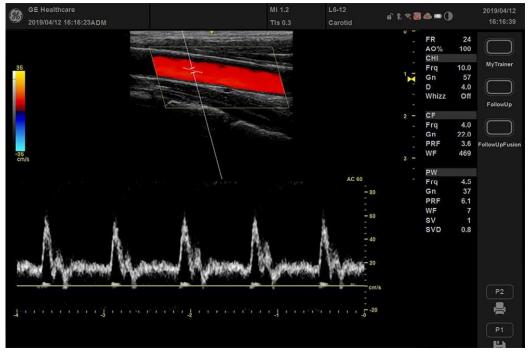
PW Doppler Mode Display -- Representative Example
